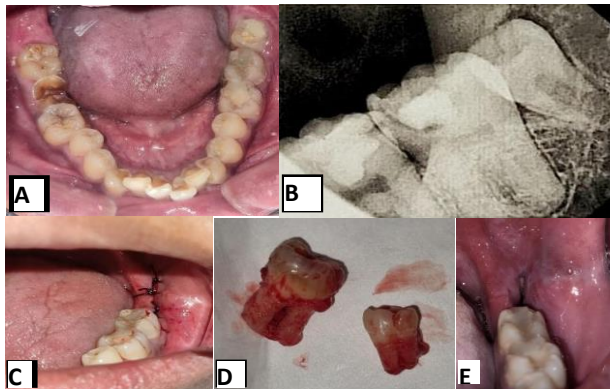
Mandibular arch; B periapical radiograph; C sutured socket; D surgically extracted third molar and distomolar; E healed socket after a week
